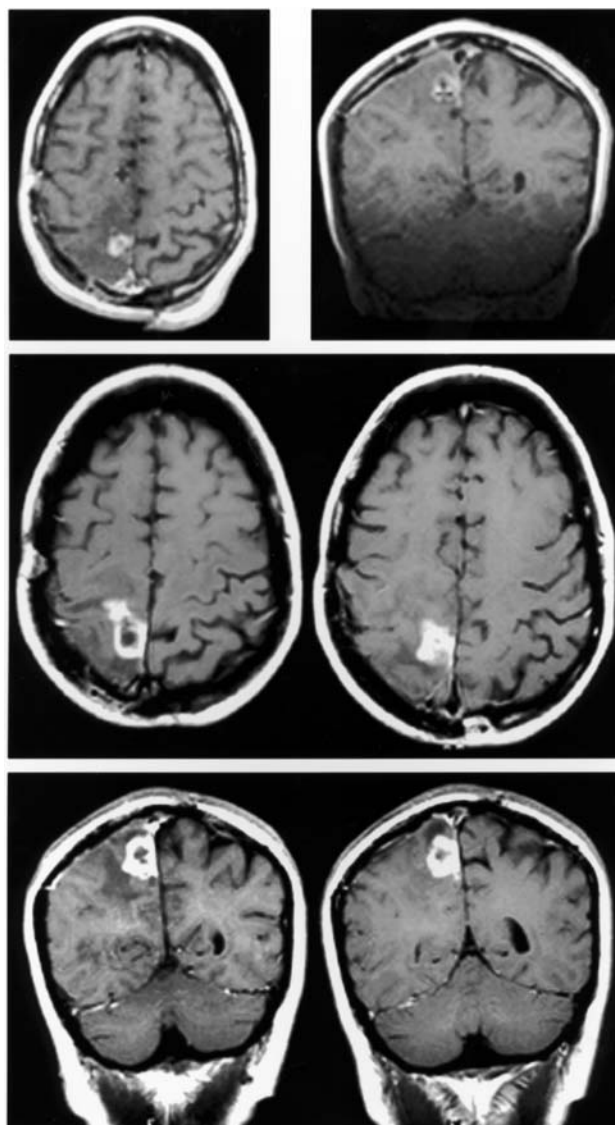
Axial and coronal T₁-weighted postgadolinium MR images obtained in a 33-year-old woman with a recurrent right parietal Grade 3 ODG. *Upper*: Images acquired at the time of radiosurgery. *Center and Lower*: Axial and coronal images obtained 5 months after radiosurgery revealing enlargement of the enhancing tumor. The patient died 8 months later.
